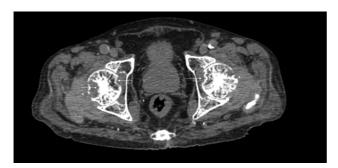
Transverse noncontrast computed tomography image shows focal articular surface erosions (*white arrows*) along the bilateral femoral head, more prominently on the left side. The osseous erosions are more prominently seen along the lateral surfaces. Intra- and periarticular soft tissue thickening is secondary to thickened synovium (*asterisks*). Hyperdense attenuation of the thickened synovium is also noted.
